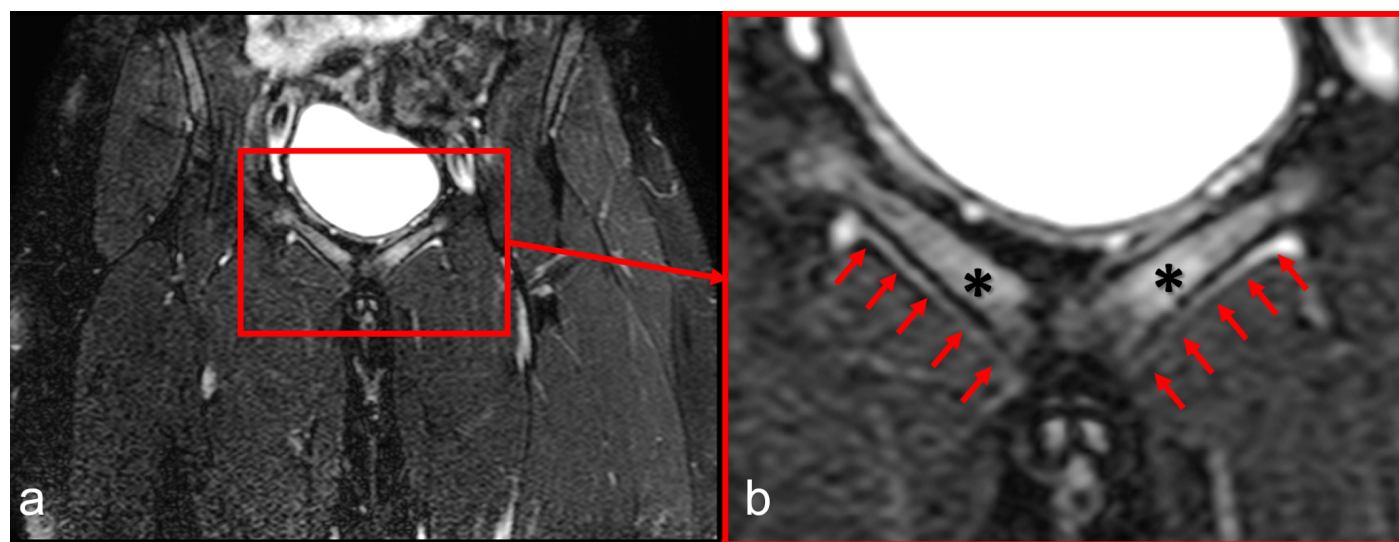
Coronal T2-weighted MR images showing a Type 3 adductor lesion (tendinopathy) in a football player. (a) General view of the pubic symphysis and bilateral adductor tendon insertions. (b) The magnified view demonstrates linear intratendinous hyperintensity (red arrows) at the enthesis of the adductor brevis, consistent with tendinopathy (enthesopathy). Asterisks (*) indicate intraosseous bone marrow edema within the pubic bodies, representing accompanying osteitis pubis.
